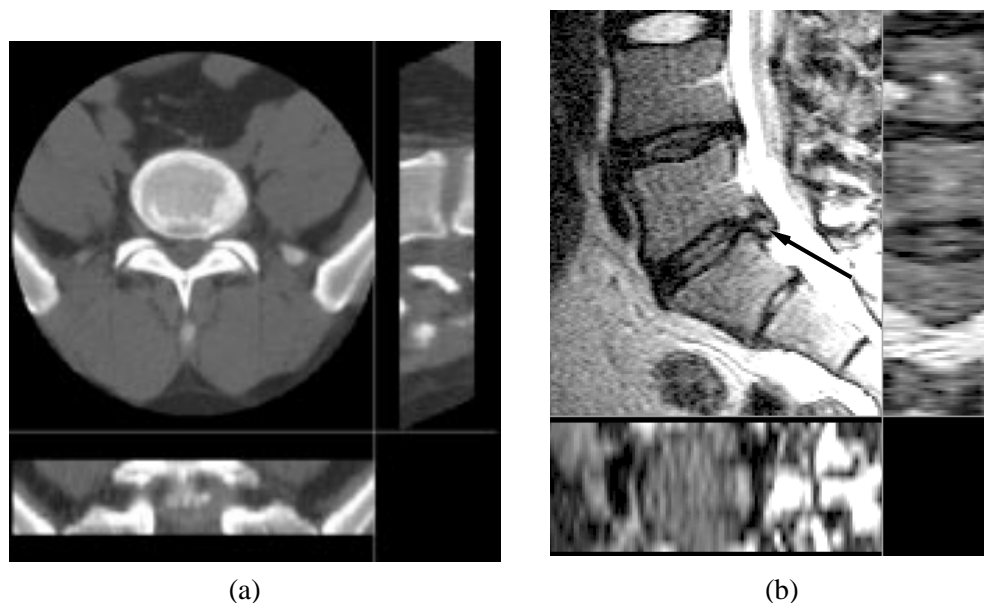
Reformatted axial, sagittal and coronal slices from the pre-operative CT volume (a) and the pre-operative MR volume (b) of a patient who underwent a percutaneous laser nucleotomy procedure. The black arrow shows the position of the prolapse in the sagittal MR slice.
